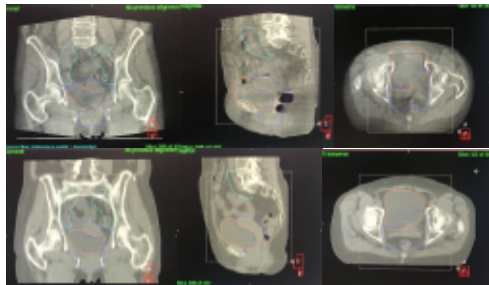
Coronale, sagittale e trasversale sezione di una CBCT scan di un paziente con inadeguata preparazione della vesciga.
